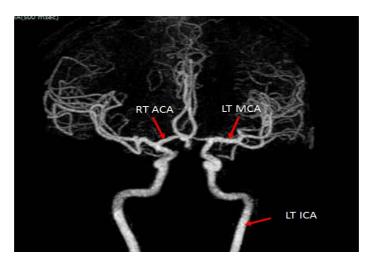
Computed tomographic angiography (CTA) 3-dimensional volume rendering (3DVR) of the anterior circulation, anteroposterior (AP) view. (Image from Radiology department, Ain Shams University)
